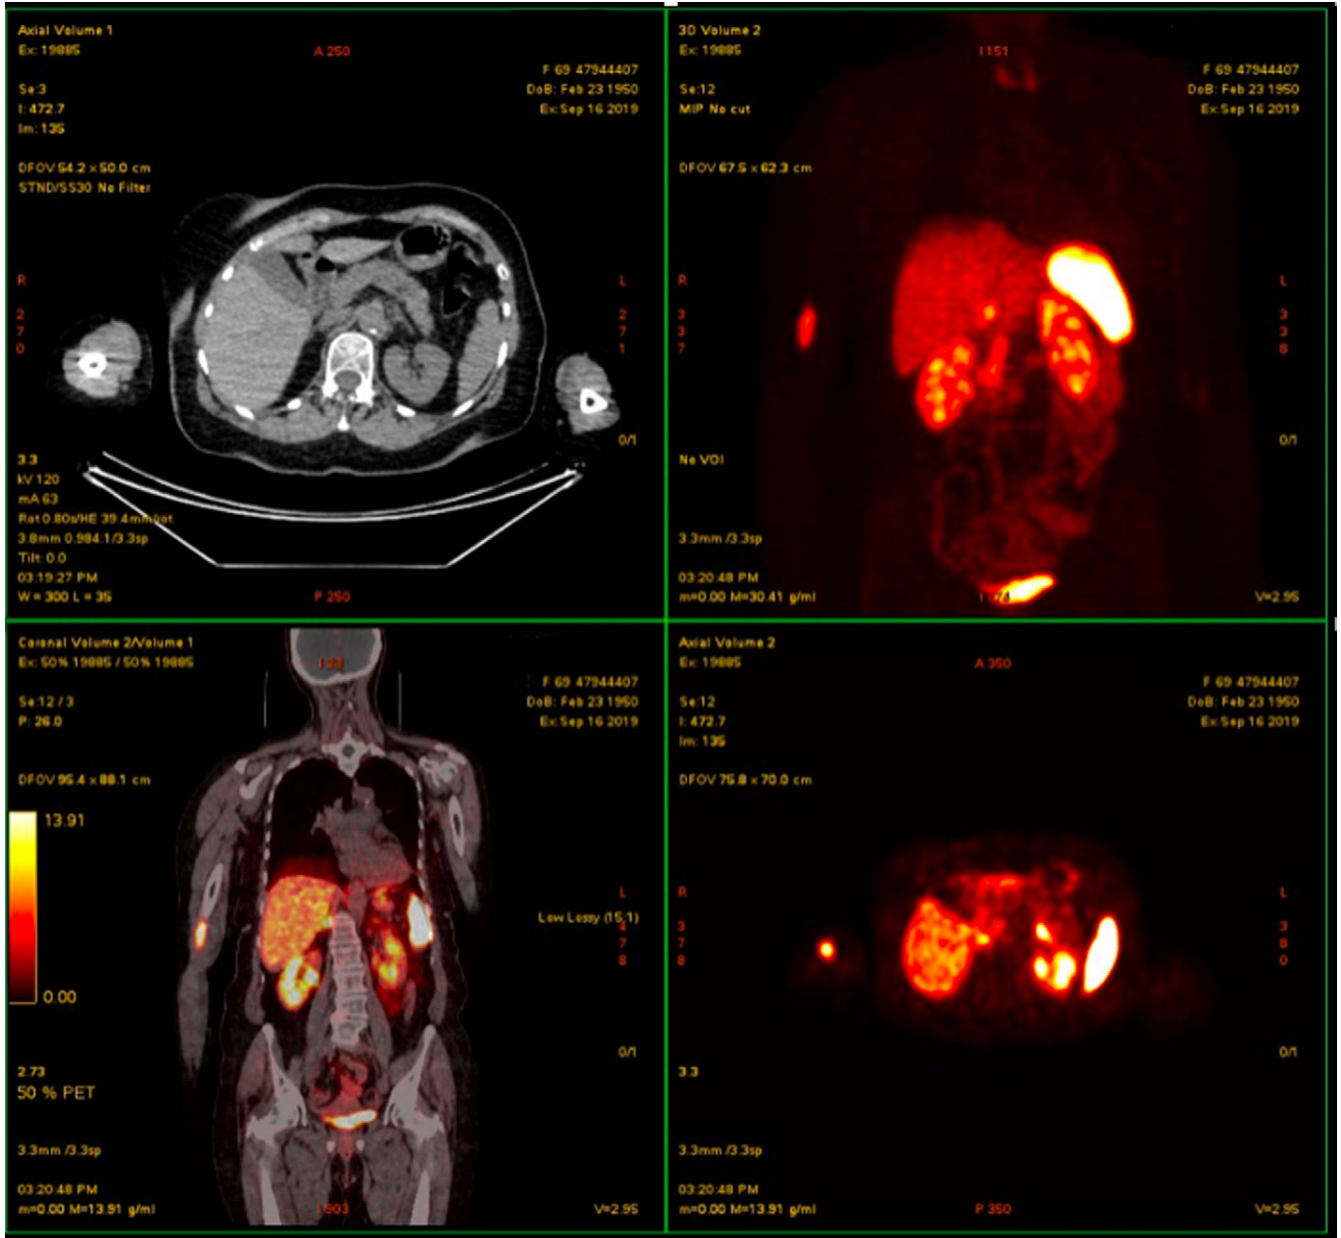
A110 MBq Ge-68 Dotatoc PET-CT [Color figure can be viewed at wileyonlinelibrary.com]
